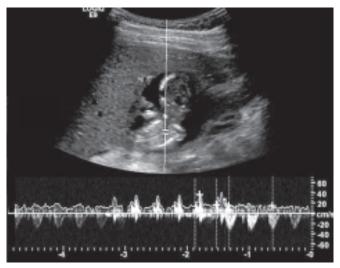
Transabdominal pulsed Doppler ultrasound demonstrates regular heart activity with frequency of 171 beats per minute
